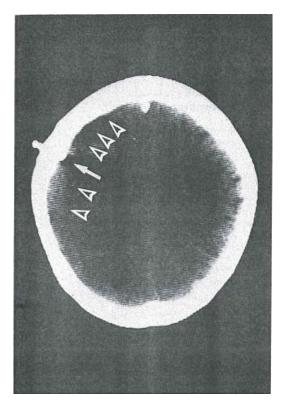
CT Scan Displaying the Subdural Needle (indicated by the arrow) during Tapping. Arrowheads point to the subdural hematoma.
